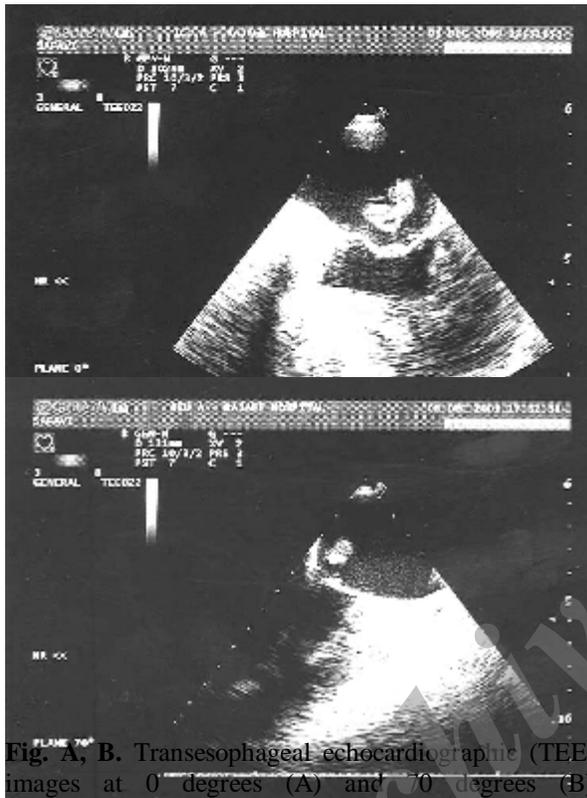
A, B. Transesophageal echocardiographic (TEE) images at 0 degrees (A) and 70 degrees (B) demonstrating ruptured papillary muscle attached to the posterior mitral leaflet and prolapsed into the LA during systole
